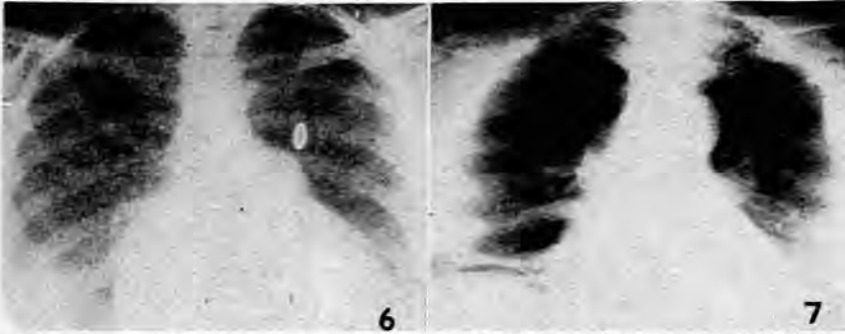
Young adult Bantu woman. Chest radiograph showing the 'ice-cube' appearance at the right base. Note the enlarged heart due to mitral disease.
